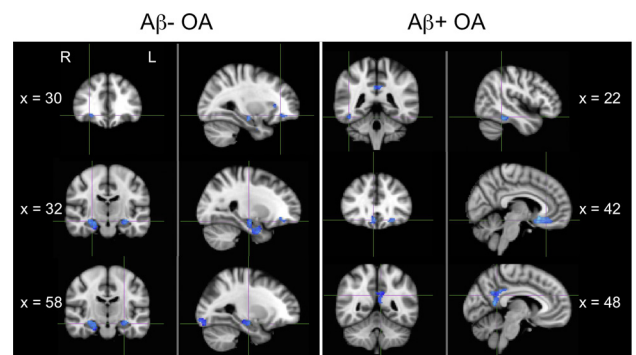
AV-1451—FDG associations by $A\beta$ status. Clusters indicate significant negative associations between AV-1451 and FDG in $A\beta^-$ (left) and $A\beta^+$ (right) older adults.
